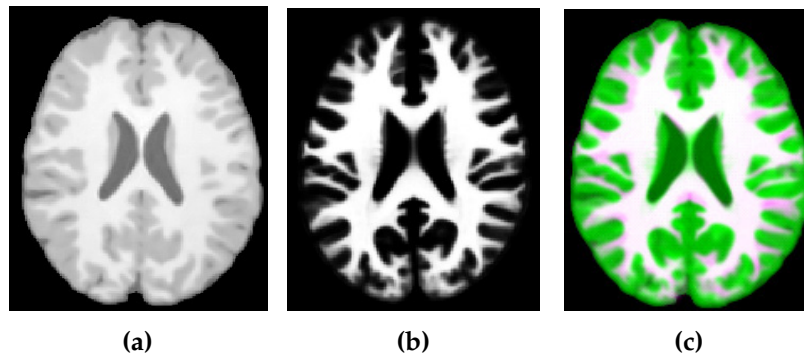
Example of atlas co-registration. (a) raw brain MRI scan in T_{1w} sequence, (b) WM prior tissue, and (c) mismatch, marked in pink.
